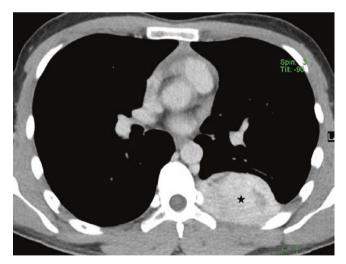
31-year-old man with pheochromocytoma in the posterior mediastinum. Axial CT image shows an avidly enhancing well-circumscribed mass (asterisk) in the paravertebral region along the sympathetic chain
